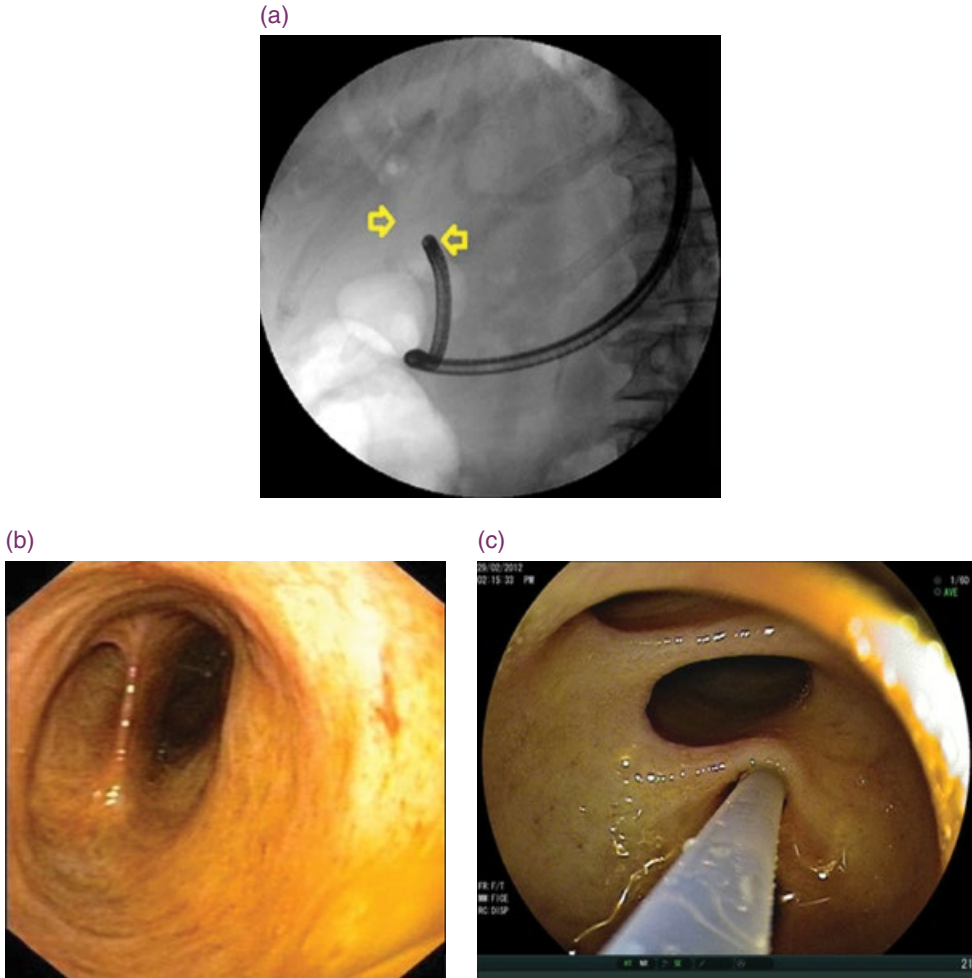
Direct cholangioscopy. (a) X-ray image demonstrating the location of the cholangioscope within the bile ducts. The arrows show aerobilia. Cholangioscopy should always be performed using either saline solution or carbon dioxide, never with air due to the risk of an air embolism. (b) Inside the bile ducts. (c) Cholangioscopy allows for direct and selective cannulation of the bile duct branches.
